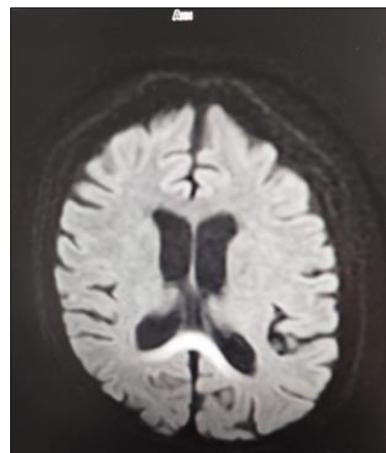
A brain MRI showed a in the splenium of the *corpus callosum*
